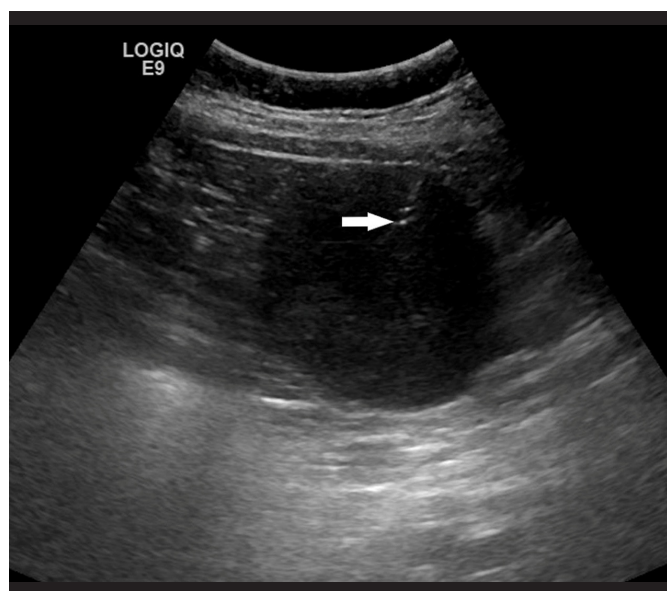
Bx with ultrasound
